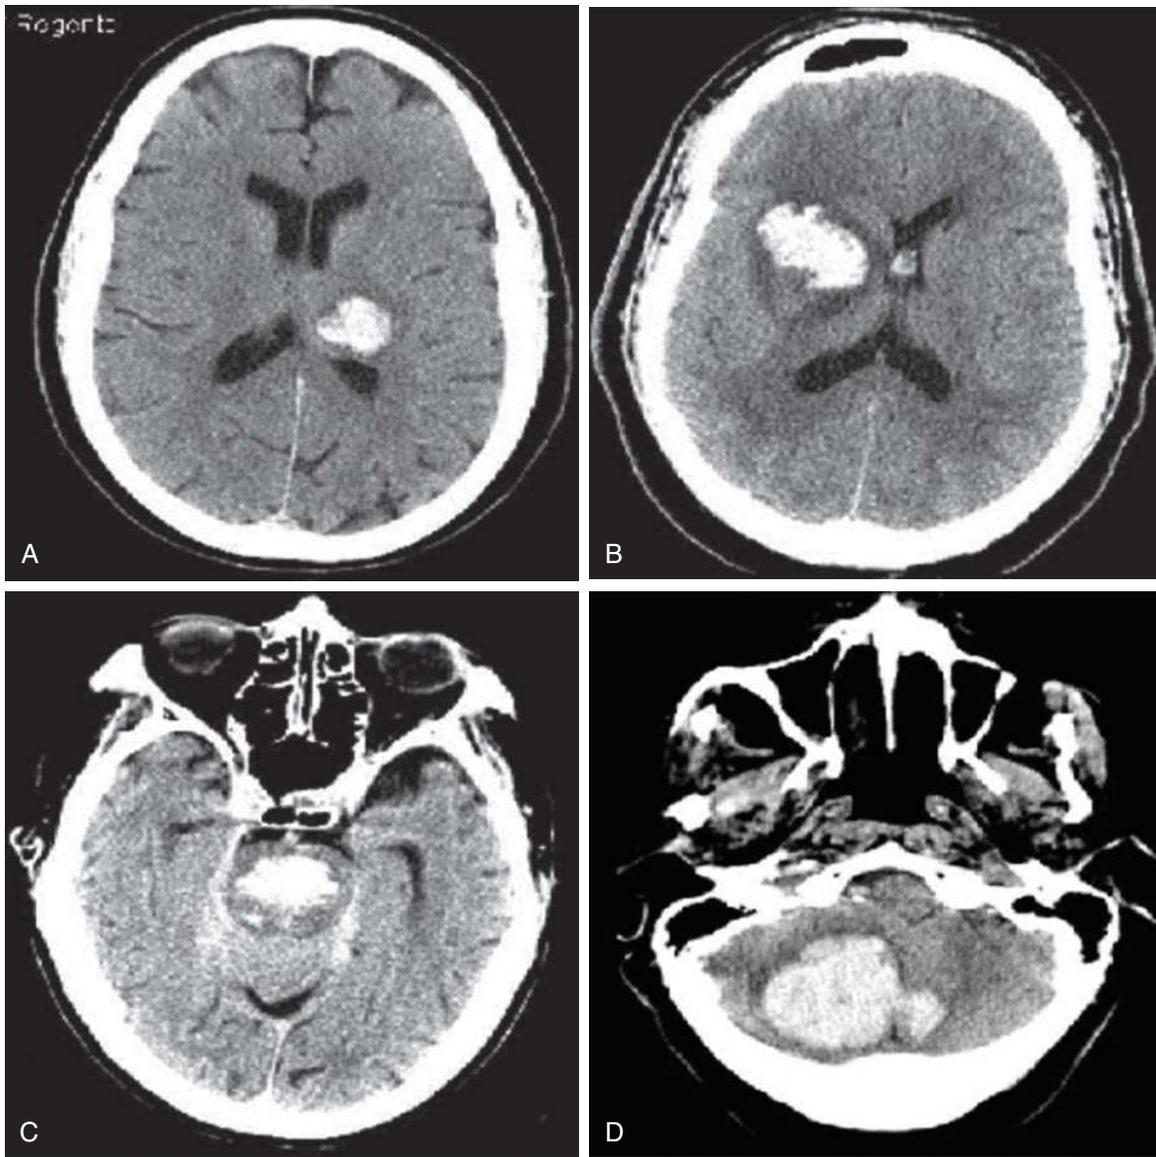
CT Scans Showing Common Locations of Spontaneous Hypertensive Intracranial Hemorrhage. A, Thalamus, B, caudate/putamen, C, pons, and D, cerebellum.
